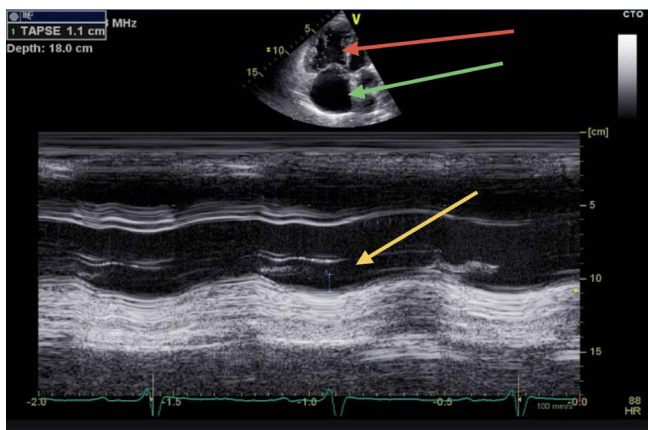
Echocardiogram Top figure: Apical four chamber view revealing enlargement of right atrium (green arrow) and right ventricle (red arrow). Bottom figure: M mode of the Tricuspid annulus. TAPSE (tricuspid annular plane systolic excursion) was noted to be 1.1 cm denoting severe decrease in right ventricular function. Normal TAPSE is > 1.7 cm Iron supplementation and gentle diuretics were administered.
